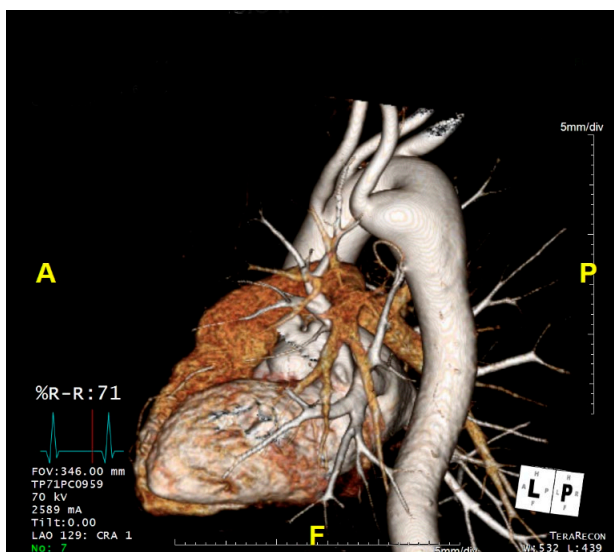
CTA – posterior view.
